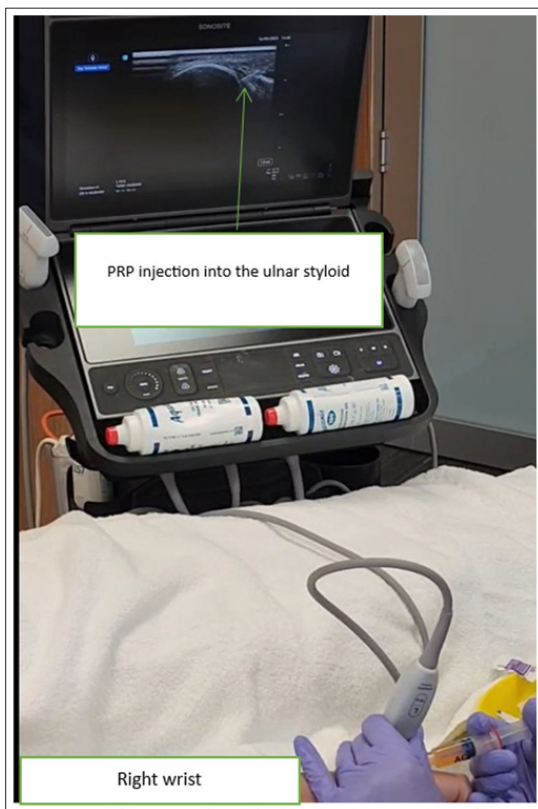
Ultrasound-guided PRP injection into the right ulnar styloid
